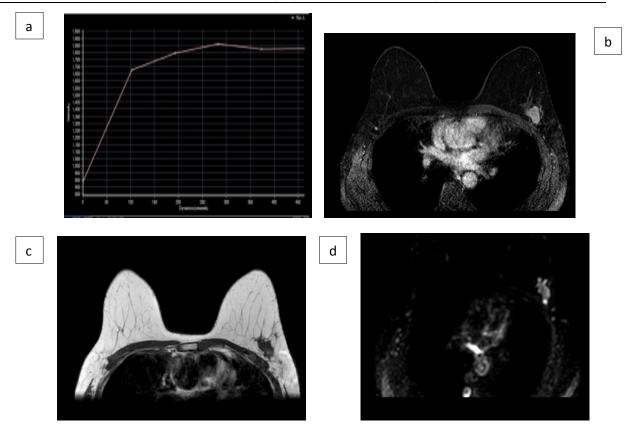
ductal carcinoma in the left breast (a)T1W-ill-defined hypointense lesion with spiculated margin (b) DWI- shows restricted diffusion (c) dynamic post contrast image- moderate to intense heterogeneous enhancement with fine central necrosis (d) type II /
